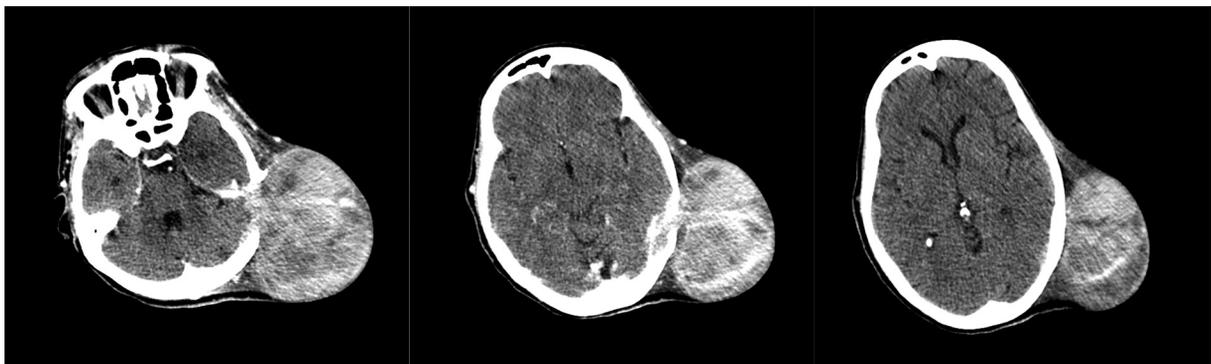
Computed tomography showing an exophytic lesion eroding the petrous portion of the left temporal bone and presenting an intense but heterogenous enhancement after contrast infusion.
